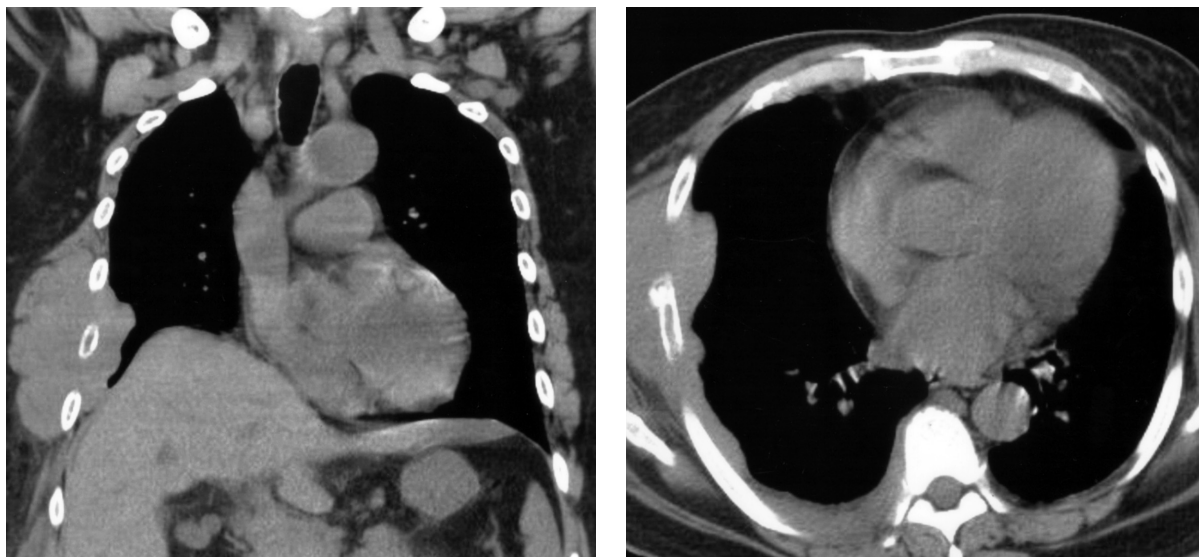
Computed tomography of the chest showing pleural wall thickening at the right lower hemithorax and a focal mass with encasement of the right 6-7th ribs. No lymphadenopathy in the mediastinum, bilateral hilar region, and axillary fossas was found.
